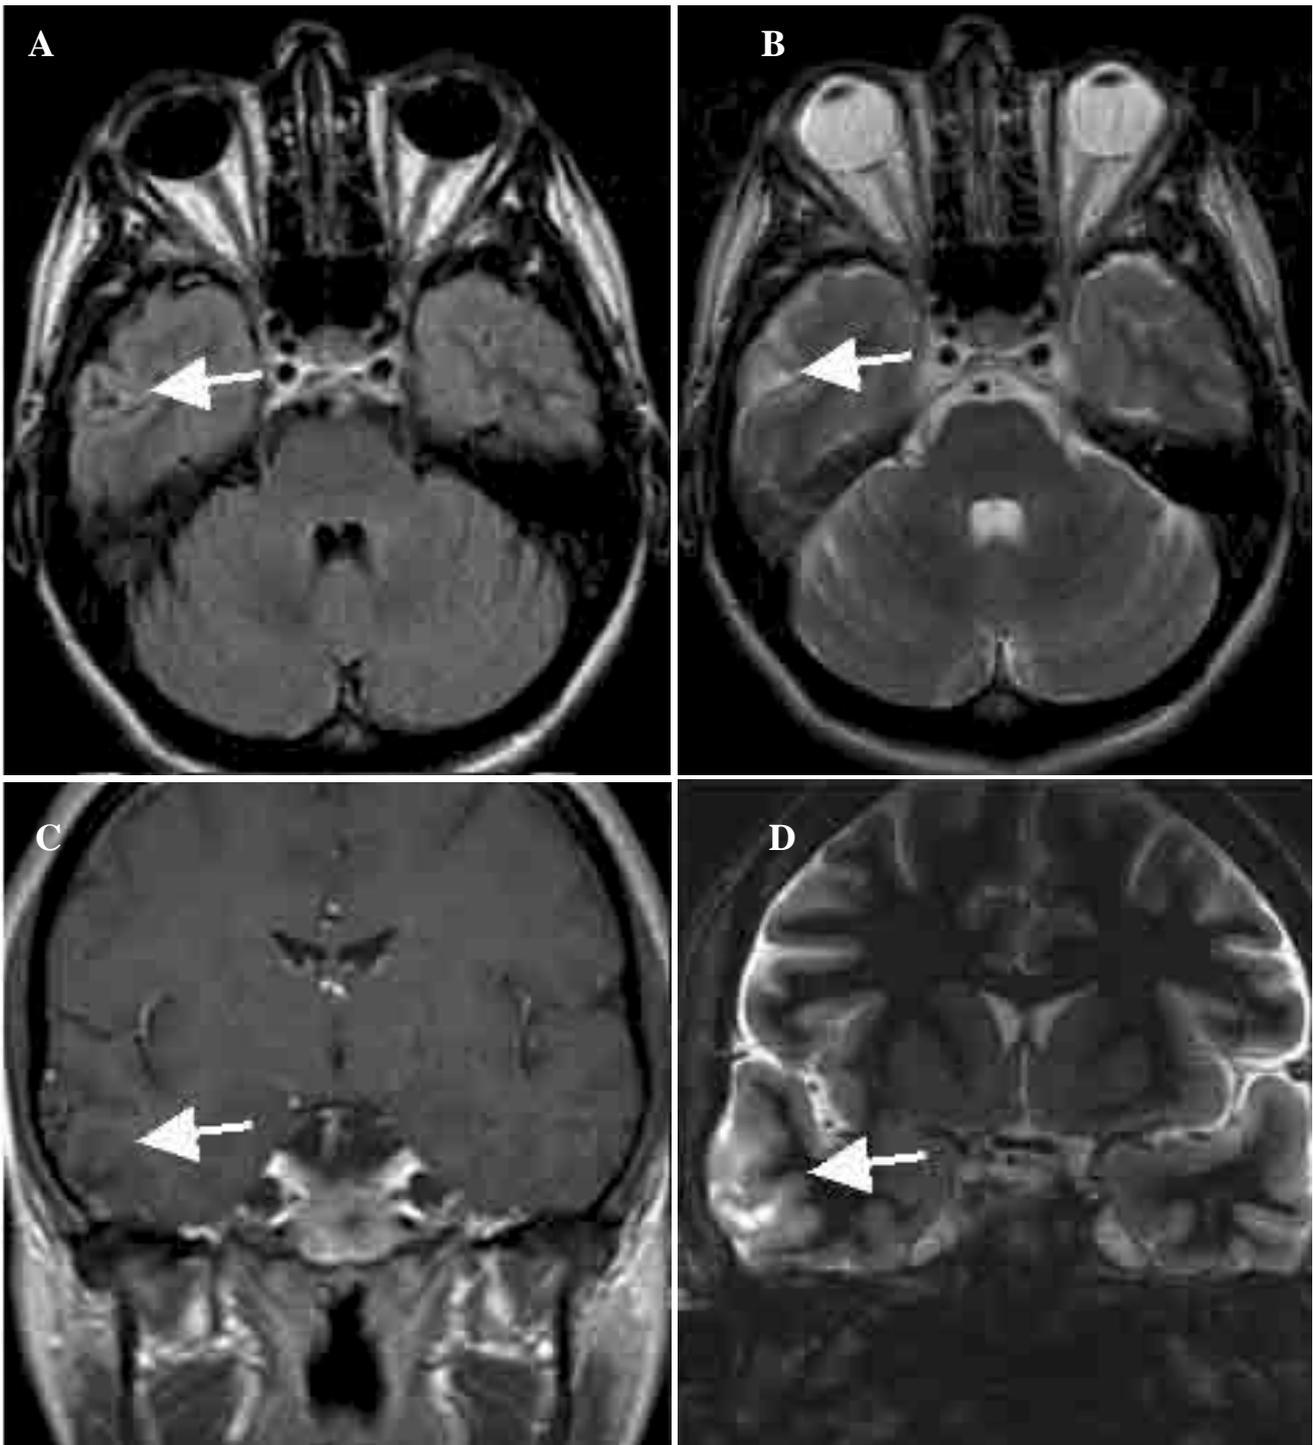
FLAIR axial (A), T2 FSE axial (B), post-contrast T1 coronal (C), and T2 FSE coronal (D) MR scans in a patient with ganglioglioma. The FLAIR and T2 axial images show area of signal abnormality in the lateral right temporal region in this patient with chronic epilepsy. The T2 FSE coronal confirms the finding to be in either the middle or inferior temporal gyri. No significant mass effect or volume loss is evident. The post-contrast T1 coronal suggests slight enhancement in the inferior aspect of the lesion. Findings were judged to be most suggestive of low grade tumor.
